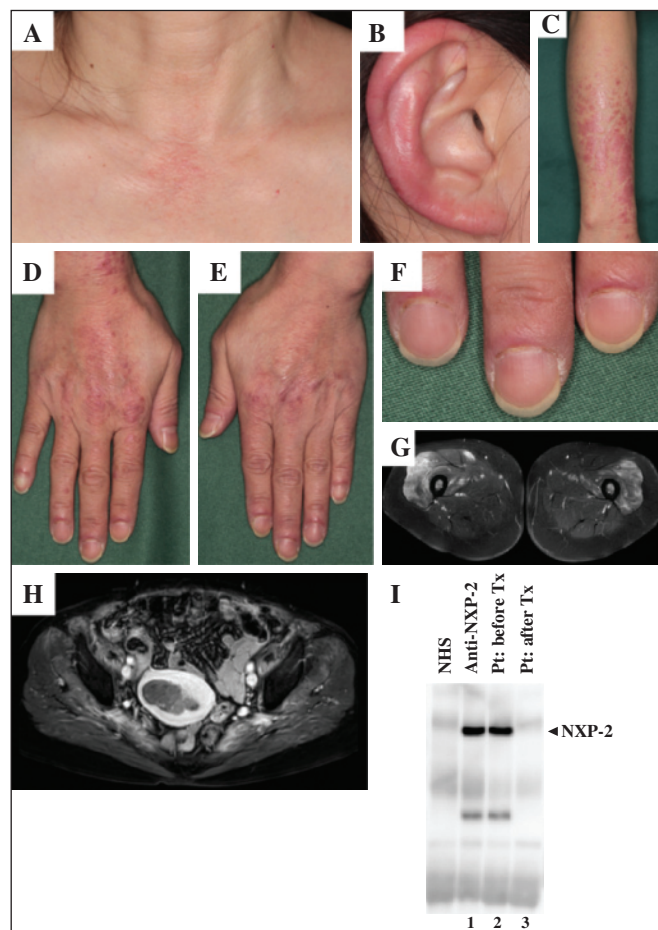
A) V-sign on the front neck. B) Diffuse erythema on the right helix. C) Slightly scaled invasive erythema on the left forearm. D-E) Gottron's sign on the hands. F) Periungual erythema and nailfold bleeding with irregular extension of the eponychium on the fingers. G) T2-weighted MRI of both thighs. H) Gadolinium-enhanced T1-weighted MRI of the pelvis. I) Immunoprecipitation/western blotting analysis showing NXP-2 protein precipitated in the serum before treatment (lane 2), but not detected after treatment (lane 3); Lane 1: anti-NXP-2 antibody-prototype serum.
